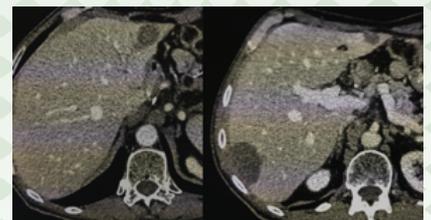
6 months follow-up CT scan
